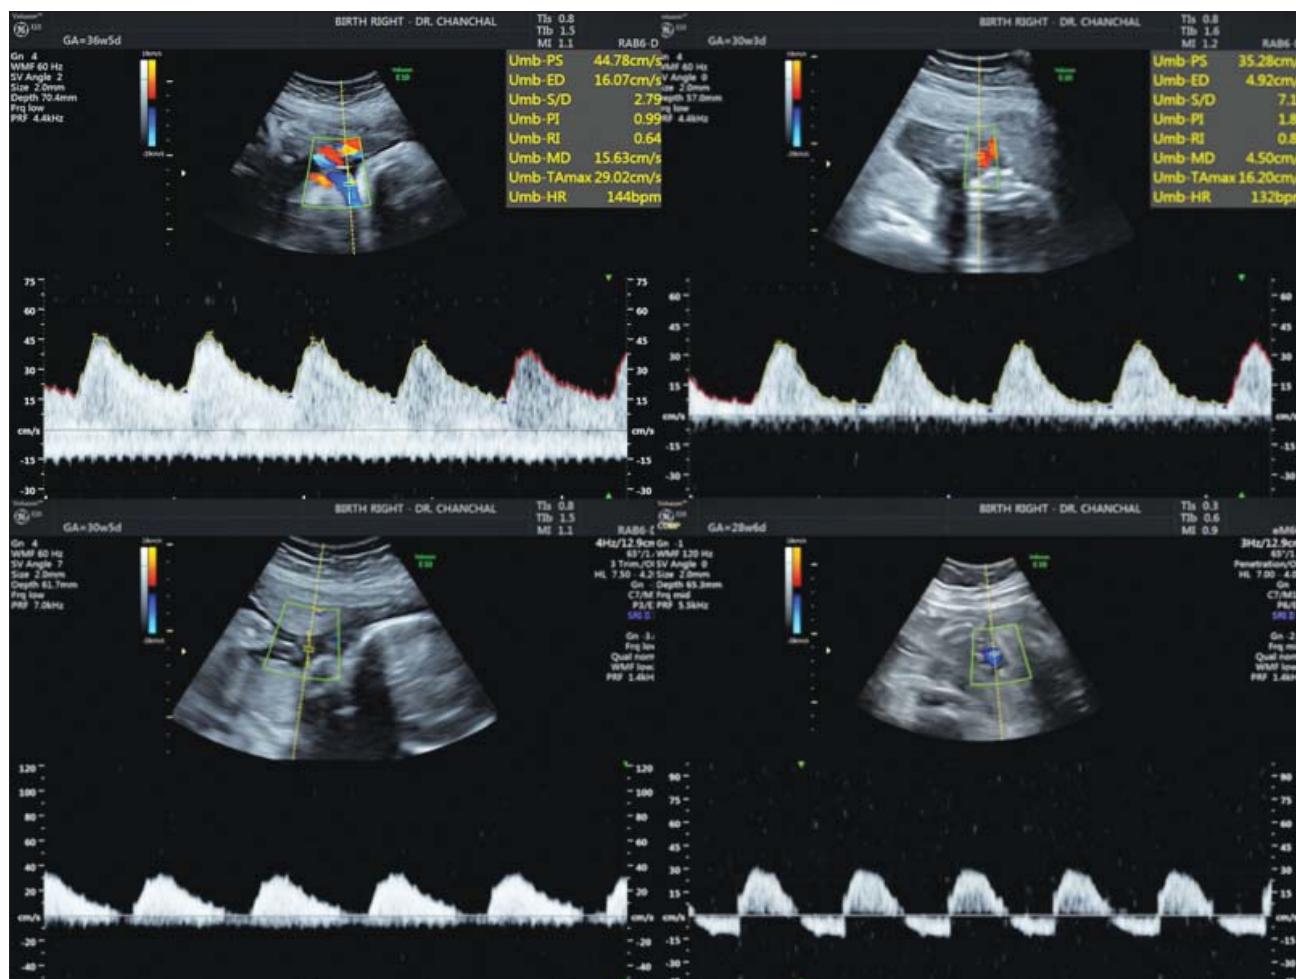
Typical deterioration in umbilical artery Doppler in early FGR (clockwise): normal waveform, increased PI, absent end diastolic flow (AEDF) followed by reversal in end diastolic flow (REDF).
